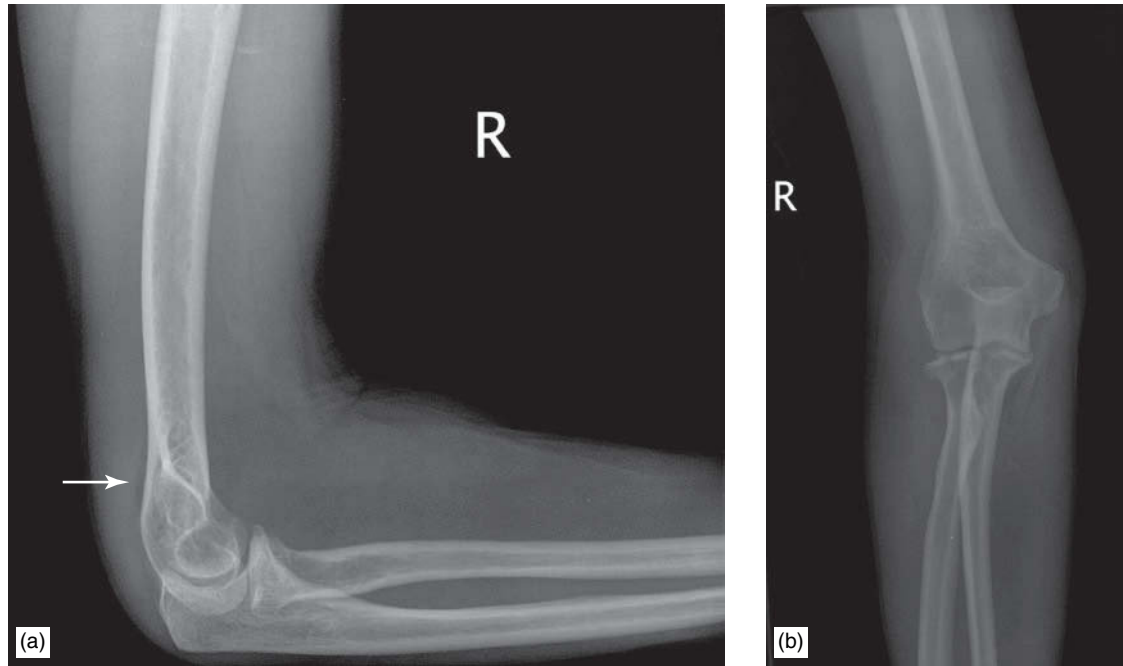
Radial head fracture. Lateral (a) and AP (b) X-rays of the right elbow showing a posterior fat pad sign (arrow) indicative of a joint effusion, and a fracture of the radial head. Courtesy: S.V. Mahadevan, MD.
